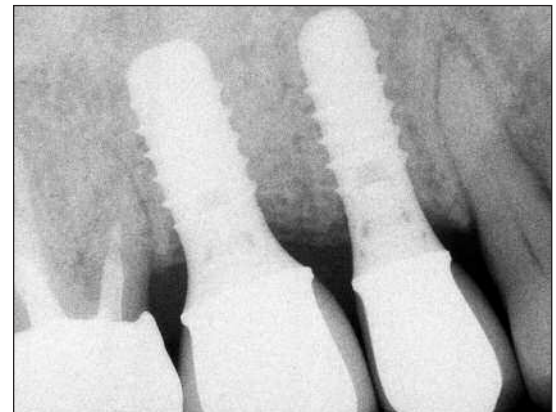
Four-year periapical radiograph showing well-integrated implants with stable alveolar bone levels.
